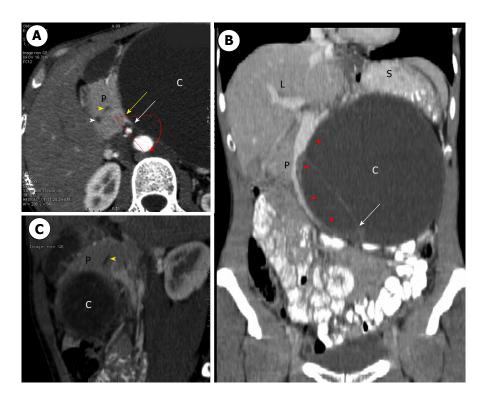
Preoperative contrast-enhanced computed tomography showing a huge cyst with septa developed close to the head of the pancreas, exophytic development to the left and downward, and rotation of the mesenteric axis. A: Axial view showing the head of the P with the intrapancreatic main bile duct (white arrowhead) and ventral pancreatic duct (vellow arrowhead). There is rotation of the mesenteric axis, as shown by the oblique plane made by the superior mesenteric artery (white arrow) and the superior mesenteric vein (yellow arrow); B: Coronal view showing thin septa within the macrocyst (white arrow) and deviation without thrombosis of the mesenterico-portal axis (red arrowhead); C: Sagittal view showing anterior development of the cyst, close to the head of the pancreas (P) and the ventral pancreatic duct (yellow arrowhead). L: Liver; S: Spleen; P: Pancreas; C: Cyst.
